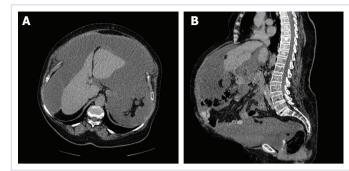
(A, B) The axial and sagittal CT scan views of the abdomen, reveal large amounts of mucinous contents and scalloping in the liver.
